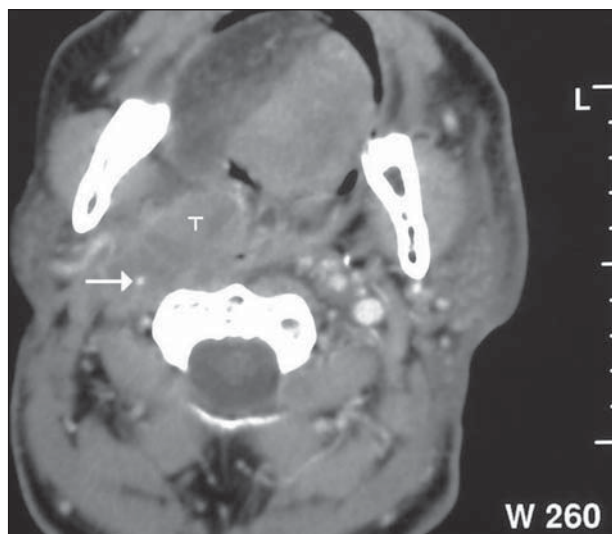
Contrast-enhanced axial computed tomography scan showing right parapharyngeal tumor (T) encasing the right internal carotid artery (arrow) and probably the right
